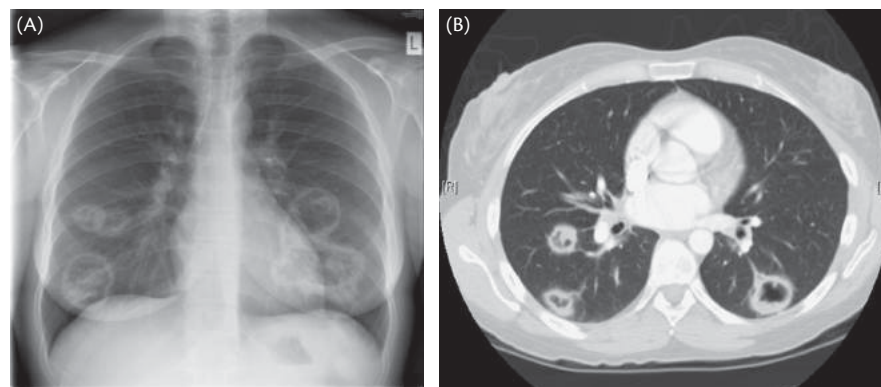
(A) Chest radiograph and (B) CT of a patient with granulomatosis with polyangiitis demonstrating multiple cavitating lung nodules.
